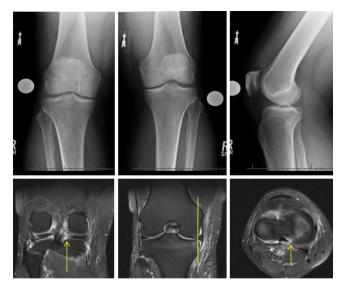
AP, Rosenberg and lateral radiographs (top) demonstrating mild medial joint line narrowing. MRI demonstrating root tear and extrusion with diffuse cartilage thinning medially.
